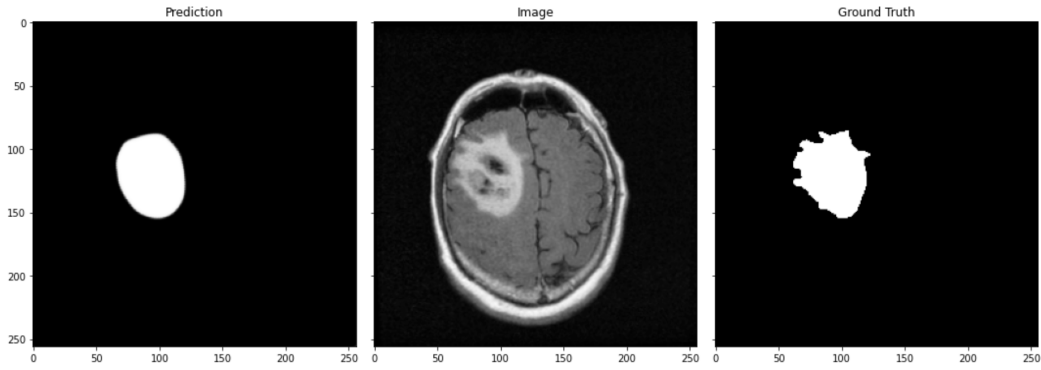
Prediction of a Brain MRI on LGG Segmentation dataset by TCIA.
